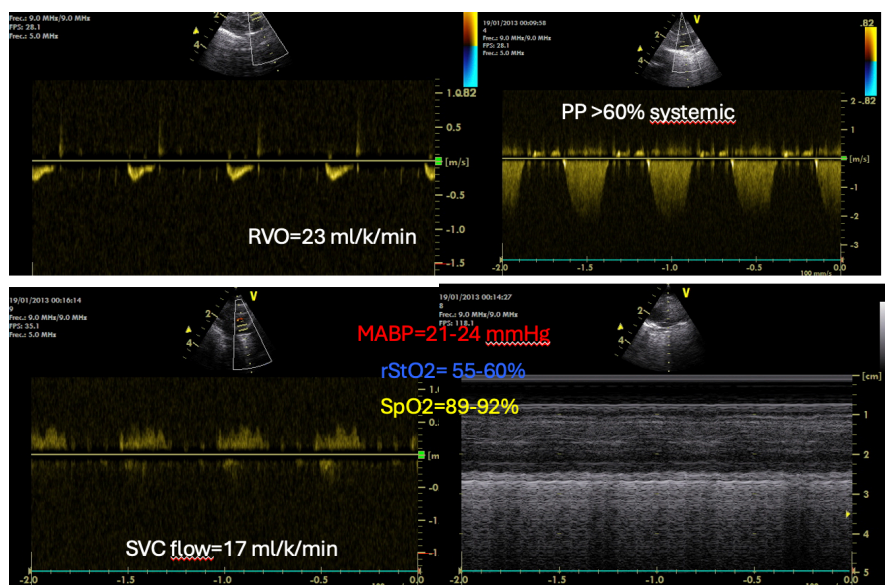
Preterm infant, 23+4 w, <24h after birth. Cerebral rStO₂ is maintained between 55% to 60% but SpO₂ and MABP are within normal ranges according to NICU policies. Echocardiography revealed very low RVO (< 150 ml/k/min) and SVC flow (<41 ml/k/min) and pulmonary hypertension (PP, pulmonary pressure >60% of systemic pressure). In such case, interventions to improve cardiac output may be used.
